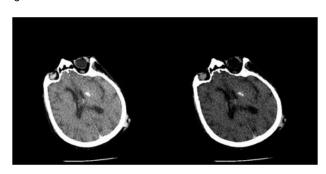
CT reconstruction images of the brain with fusion CT technique with window settings for parenchyma (left) and angiography (right).
